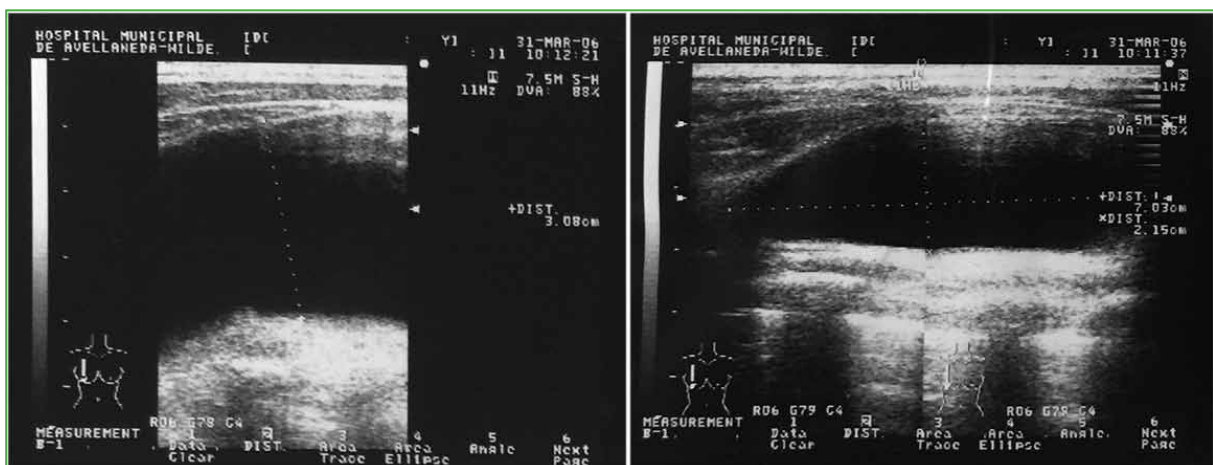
Ultrasound measurement of the bursa.
